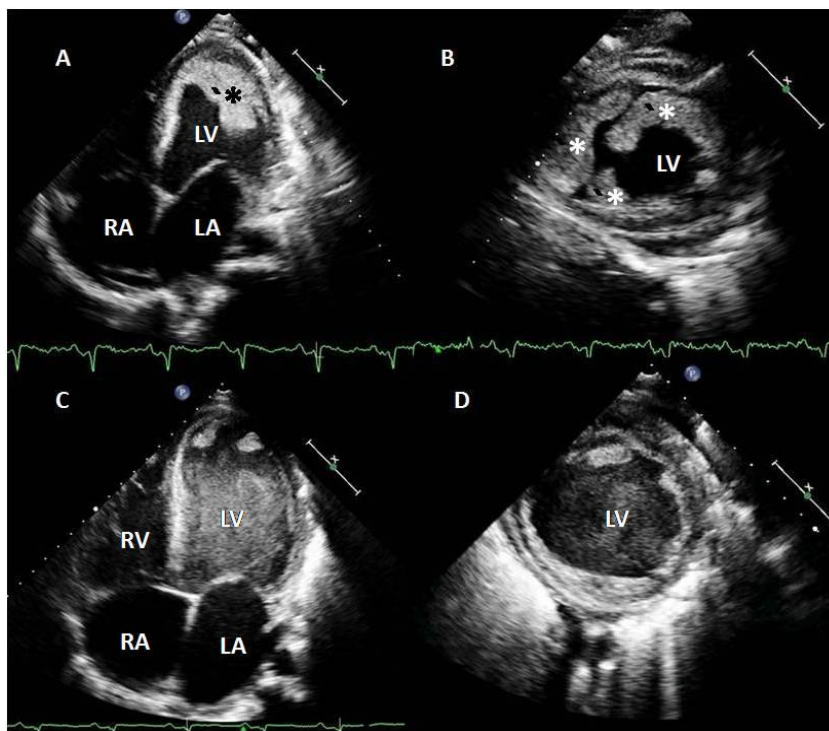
A. Apical 4-chamber view showing a huge parietal thrombus, covering the anterior, lateral and posterior walls (asterisk). B. Short axis showing a huge thrombus (asterisks). C. Apical 4-chamber after 3 weeks of treatment showing a drastic reduction in the thrombus and the presence of marked self-contrast. D. Short axis showing a reduction in the thrombus and the presence of self-contrast. RV – right ventricle; LV – left ventricle; RA – right atrium; LA – left atrium.
